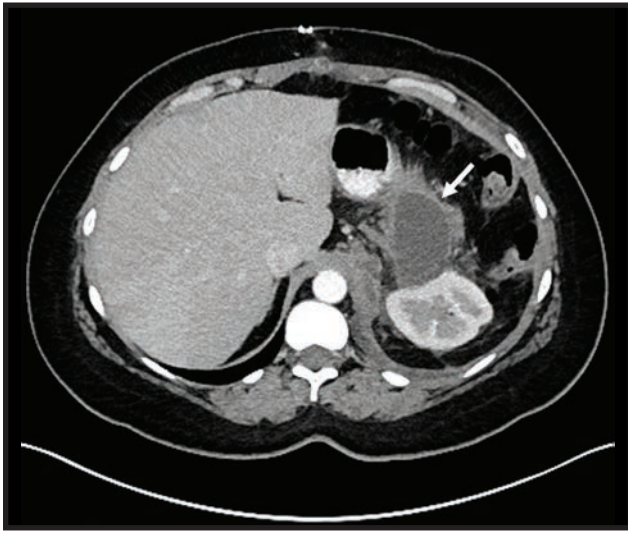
CT demonstrating a 5.8 cm rim-enhancing peri-pancreatic fluid collection (arrow) three weeks after left adrenalectomy with distal pancreatectomy and splenectomy
